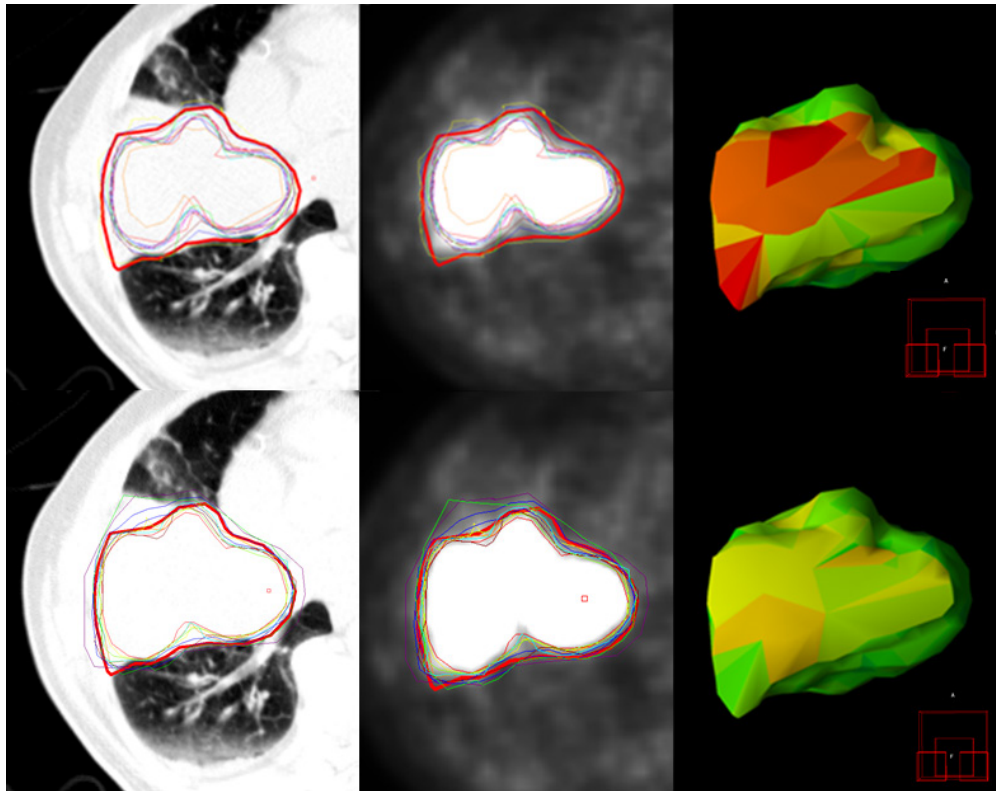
Results from contouring the GTV in case 6 before (top images) and after (bottom images) the complete training. From left to right an image slice in the axial plane from CT, PET, and a 3D model of the expert contour with mean surface distance errors projected (from blue to red, corresponding with a mean absolute surface distance of 0 to >1 cm). The bold red line represents the GTV_{exp} .
